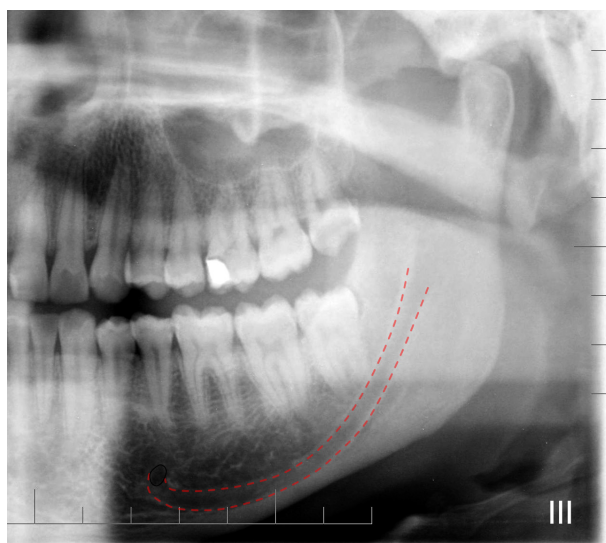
Radiographic image of the mandibular canal type 3 (red traces) in relation to the lower molars apices according to Nortjé et al. (10) classification.
